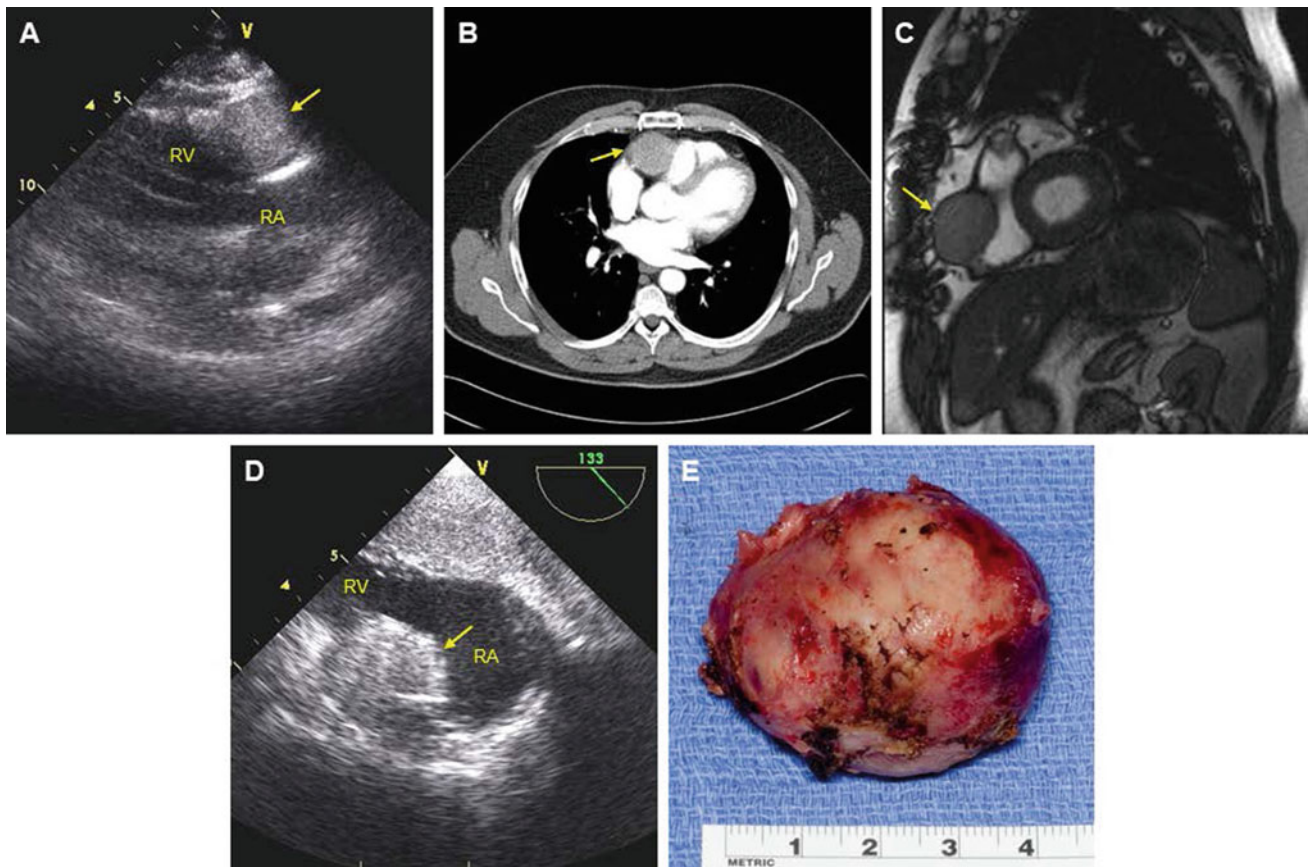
Metastatic carcinoid tumor infiltrating the RV anterior free wall is visualized by transthoracic echocardiography (RV inflow view) (A), cardiac CT (B), cardiac MRI (C), transesophageal echocardiography (transgastric view) (D), and after surgical excision (EE)
